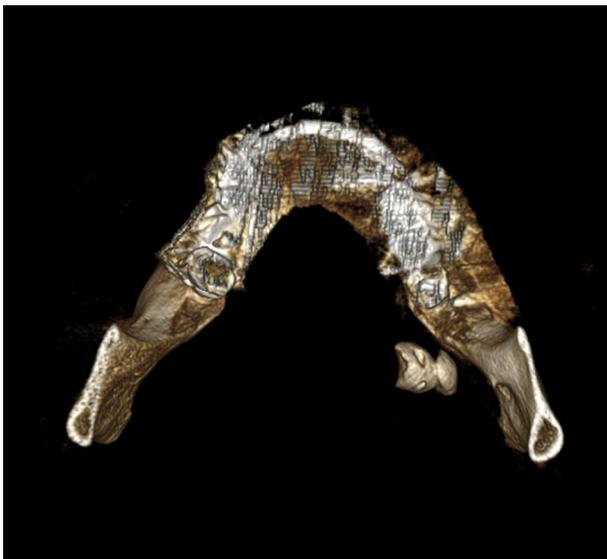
Patient 2. Cone-beam computed tomography image, 3-dimensional superior view.
